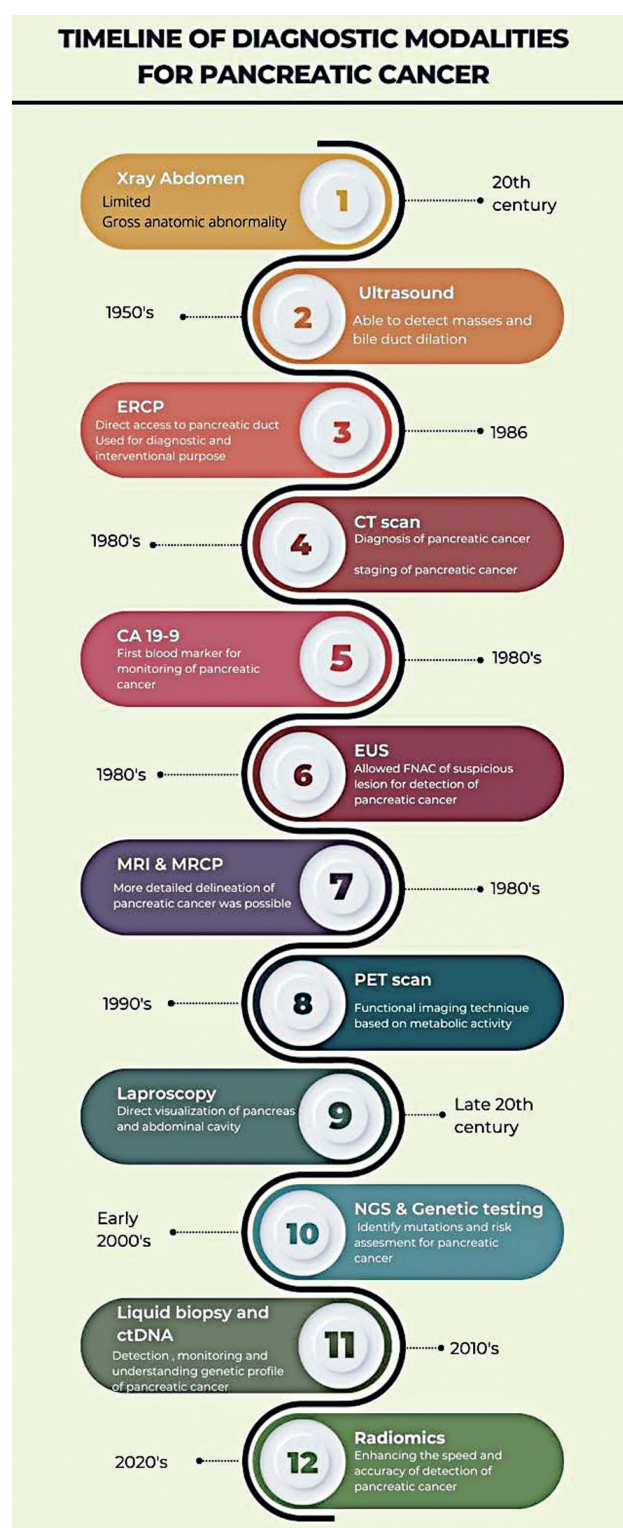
Timeline of pancreatic cancer diagnostic modalities. Figure made with Canva online (www.canva.com). ERCP, endoscopic retrograde cholangiopancreatography; CT, computed tomography; EUS, endoscopic ultrasound; MRI, magnetic resonance imaging; MRCP, magnetic resonance cholangiopancreatography; PET, positron emission tomography; NGS, next generation sequencing; ctDNA, circulating tumor deoxyribonucleic acid.
